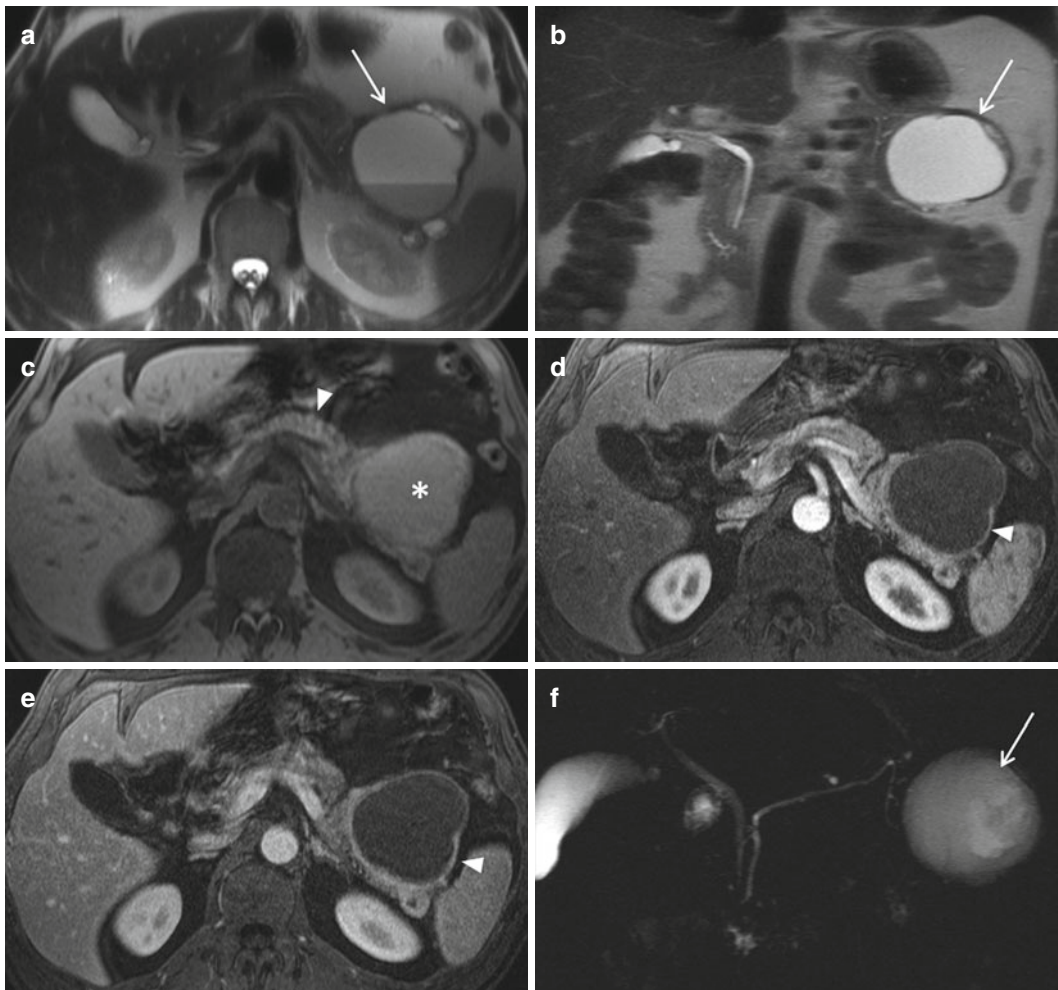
A 58-year-old patient with cystic pancreatic neuroendocrine tumor. (a, b) Axial (a) and coronal (b) T2-weighted images: a hyperintense cystic mass (*arrow*) is visible in the pancreatic tail; intracystic fluid contains blood and presents two different signal intensities, because of the presence of different hemoglobin metabolites. (c) Axial T1-weighted GRE image with fat saturation: intracystic fluid (*asterisk*) is
